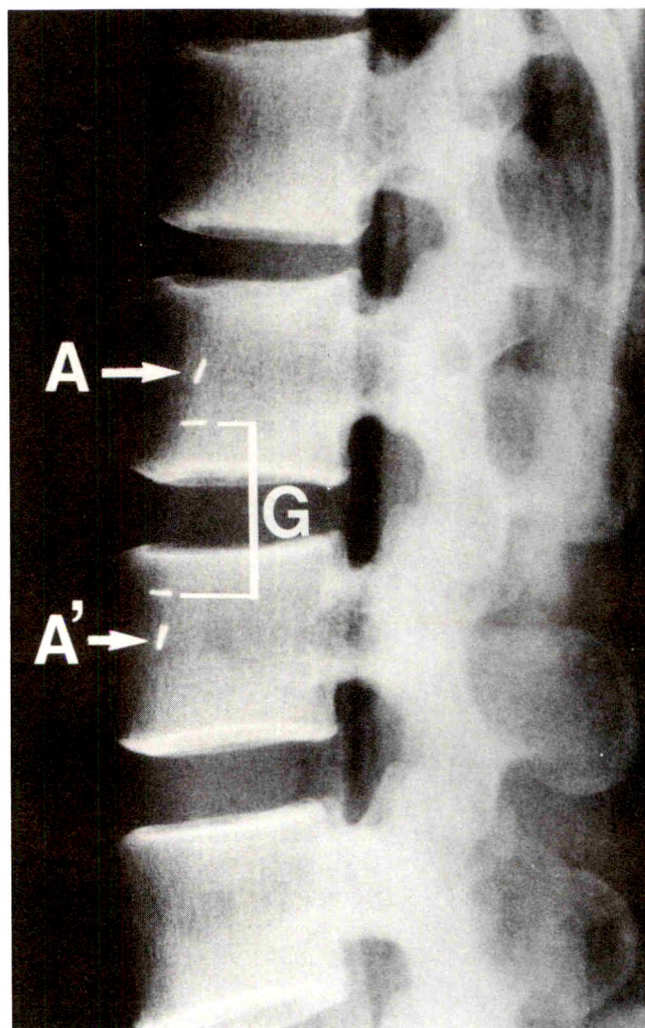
An x-ray film showing the lateral aspect of the lumbar vertebral column and the applied metal clips. The metal clips were applied under direct vision before the removal of the vertebral column as a single block. Diagonally placed clips show the points at which the sympathetic trunks cross the lumbar arteries at the second (A) and third (A') lumbar vertebral bodies. The horizontally placed clips were applied immediately above and immediately below the anatomic enlargement in the sympathetic chain, represented by "G," which indicates the location of the sympathetic ganglion.
